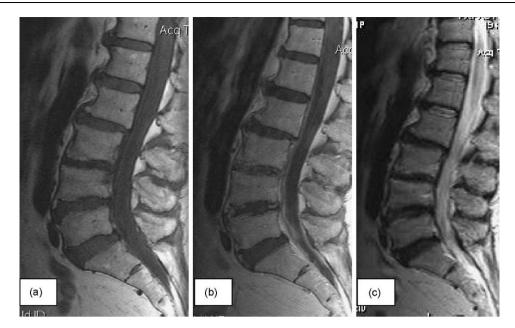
Follow-up MRI at 12 months from patient 6: sagittal T1 before (a) and after (b) contrast administration and T2 images (c). There are no signs of infection.
